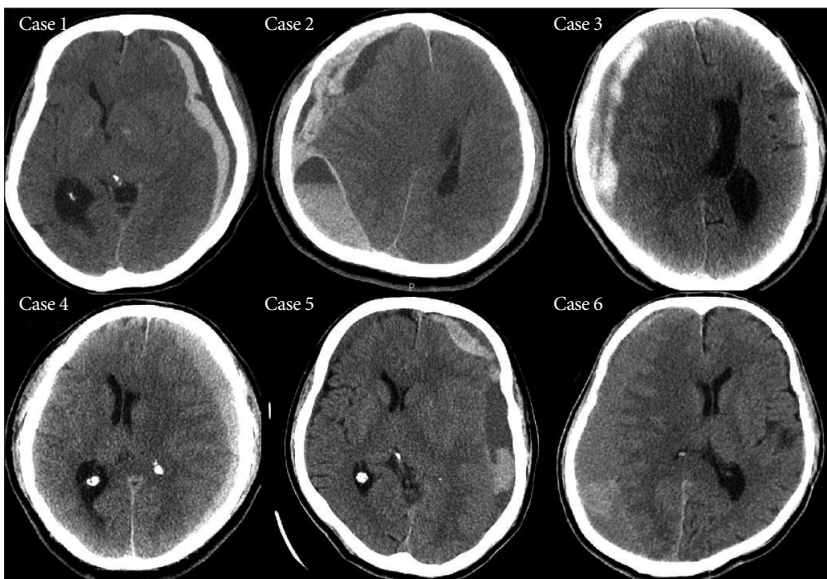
Preoperative CT scans of the acute-on-chronic subdural hematoma (case 1 to 6).
